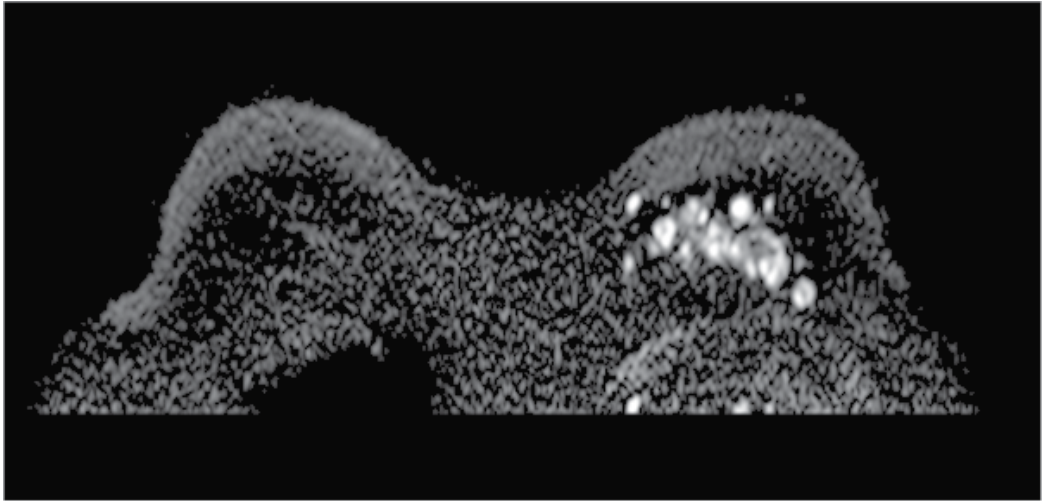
Diffusion weighted image of HR-MRI; Multiple mass-like high signal intensities are seen in the left breast.
